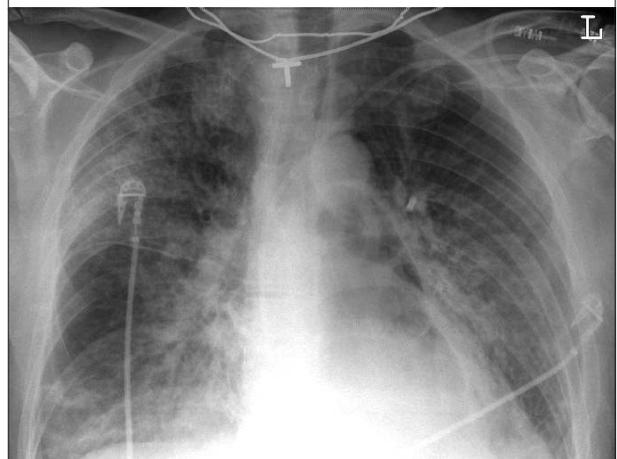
Chest radiograph showing a gas configuration in the left hemithorax
